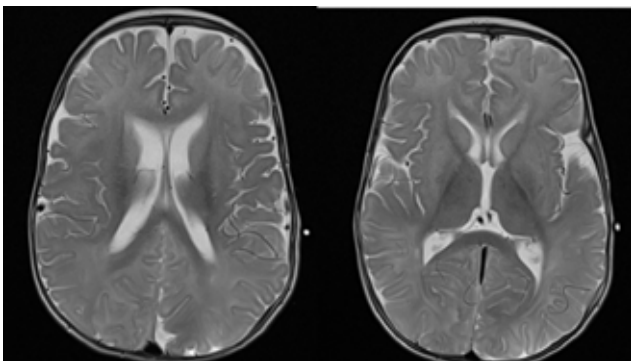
MRI findings of the endocranium of patient 5: multiple bilateral cortico-subcortical changes in all cerebral lobes, signal changes in basal ganglia and thalamus
